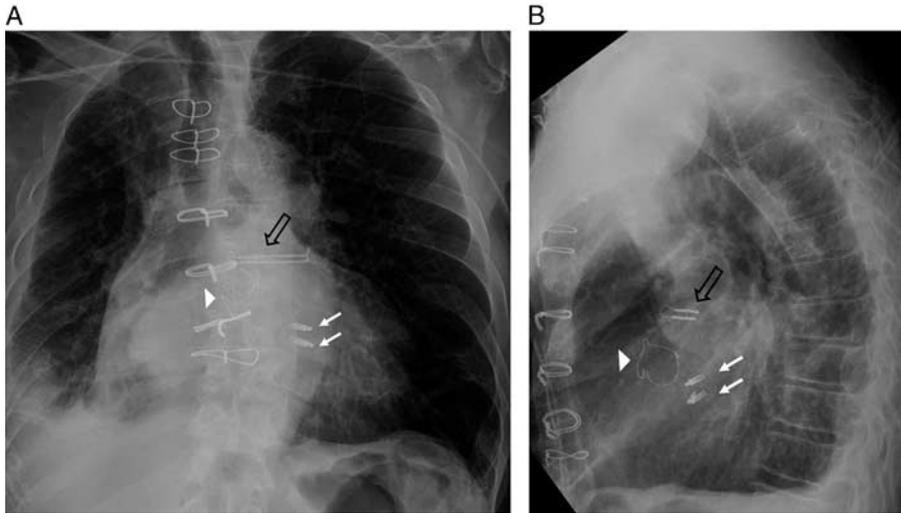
Mitral regurgitation repaired with mitral clip: frontal (A) and lateral (B) radiograph after mitral valve repair with 2 MitraClips (white arrows). The patient had prior surgical aortic valve replacement (white arrowhead) and LAA exclusion via AtriClip (open black arrow).
